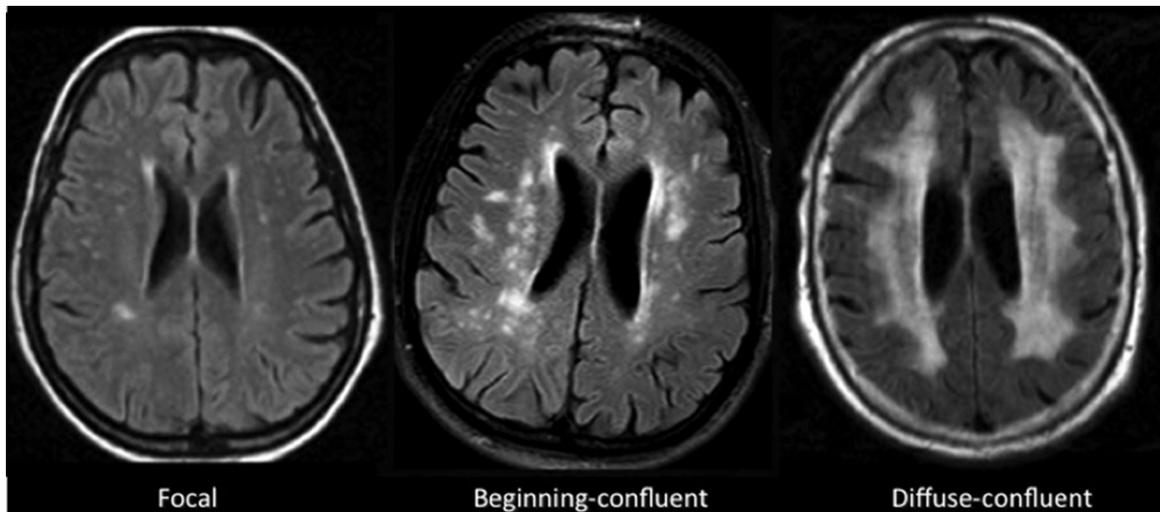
Axial T2-weighted FLAIR images show the WMH rating scale for small-vessel disease.
